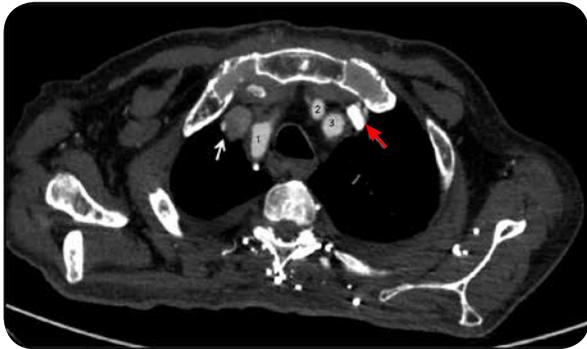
Angio CT, axial section. Five vascular structures at supra-aortic vessels are identified: right superior vena cava (white arrow), left superior vena cava (red arrow), brachiocephalic trunk (1), left common carotid artery (2) and left subclavian artery.
